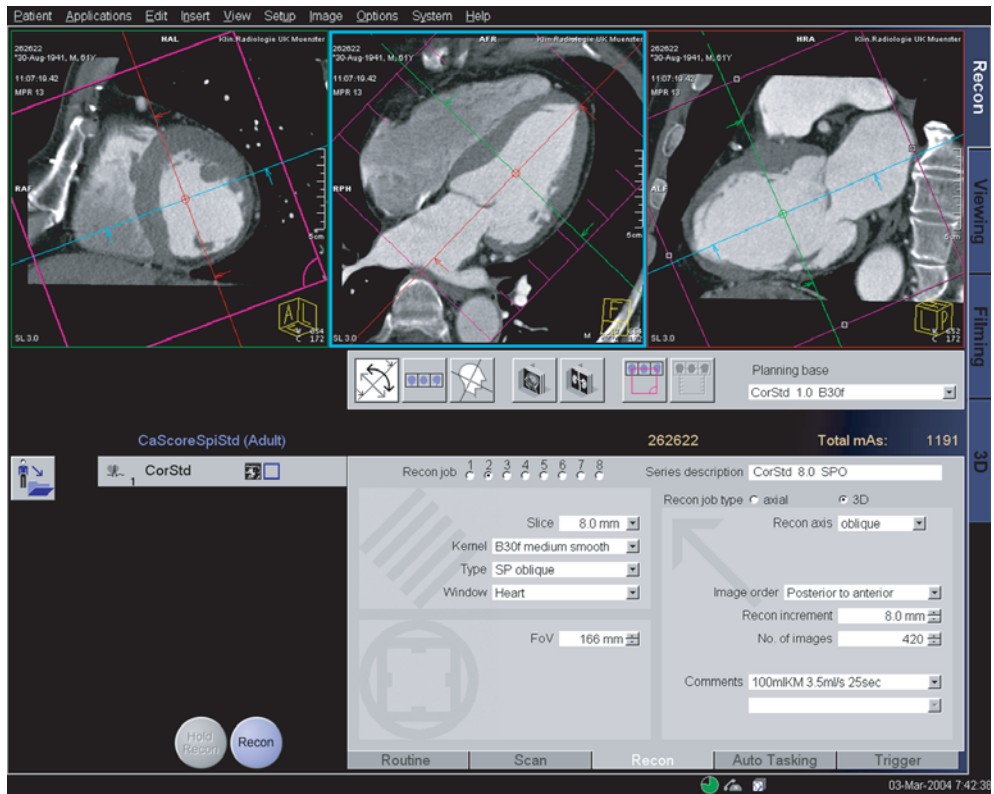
Direct generation of short-axis images from a multi-slice CT data set. a The appropriate orientation is interactively defined and a series of short-axis images is produced without the need to generate primary axial reformations. b Direct reconstruction of short-axis MPRs from mid-ventricular level images allows for easy identification of maximum contraction and maximum dilatation. Systolic and diastolic image series are then used for ventricular volume measurement
